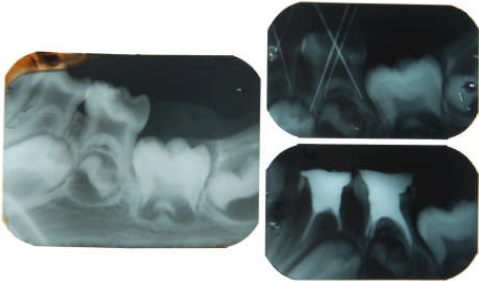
IOPA radiographs showing taurodontism of lower left first and second primary molars, pre and post pulpectomy.
